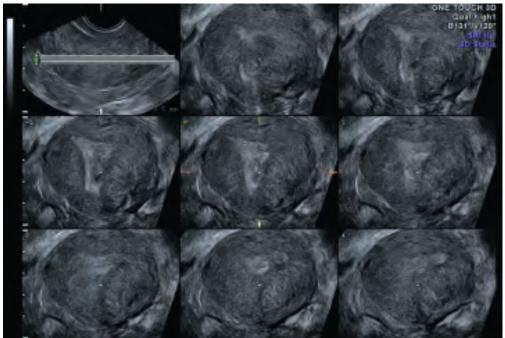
3D Tomographic Ultrasound Imaging studies in the same case as in Figure 56.30E reveal a markedly interrupted endometrium confirming extensive synechiae in the cavity
